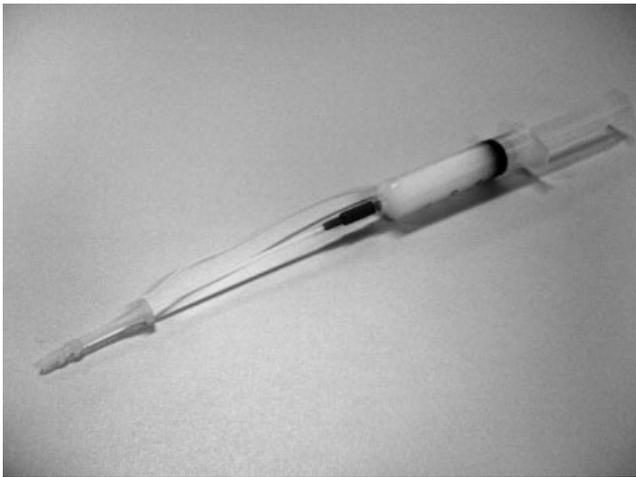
Syringe with foam and cervical applicator for the hysterosalpingo-foam sonography technique.
